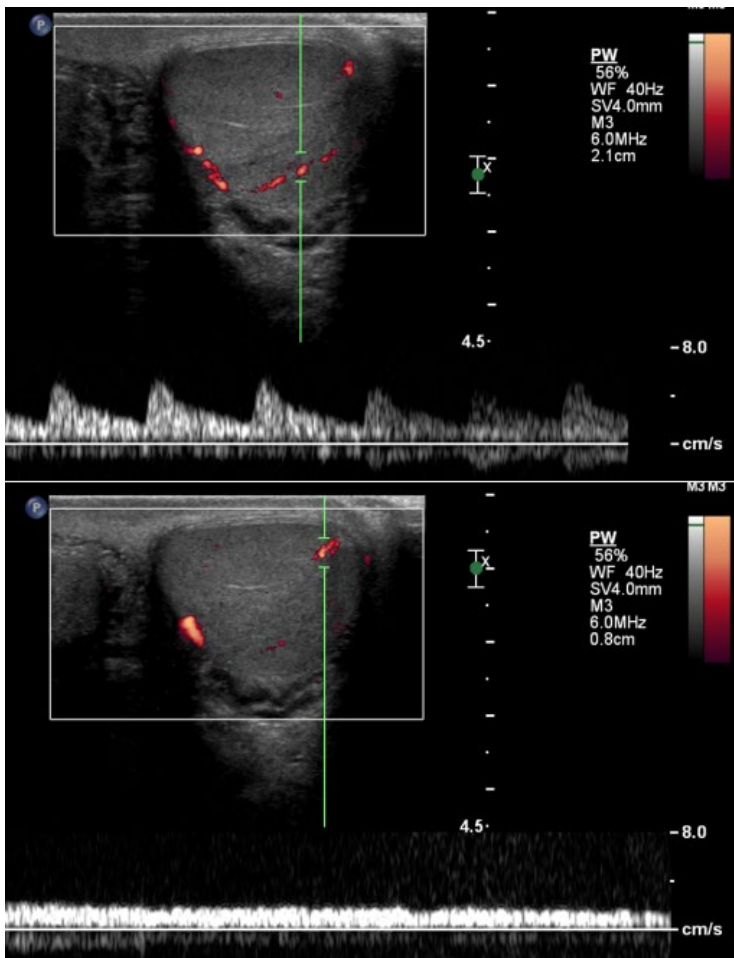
Arterial (upper image) and venous (lower image) spectral Doppler tracings. A loss of venous flow is often the first sign of torsion.
